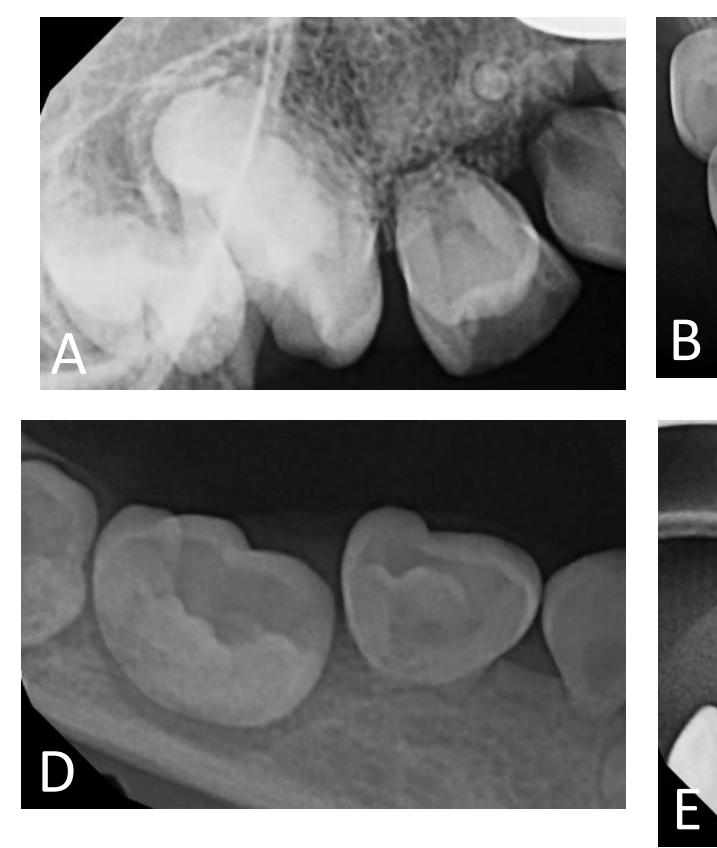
Radiographic examination
